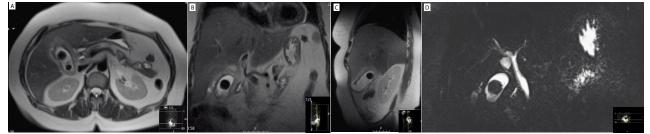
(A) Axial, (B) Coronal and (C) Sagittal sections of an abdominal MRI scan. A large calculus can be seen at the fundus of the gallbladder, which is distended, with a thickened wall and surrounding edema. (D) MRCP reveals an unobstructed common bile duct, with passage of contrast to the small bowel.
